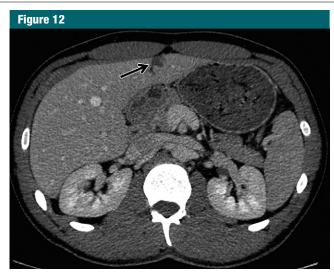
Image in a 34-year-old man with pseudolesion around falciform ligament. Axial contrast-enhanced CT at the arterial phase (not shown) and portal venous phase showed a low attenuation area (arrow) on both phases.
